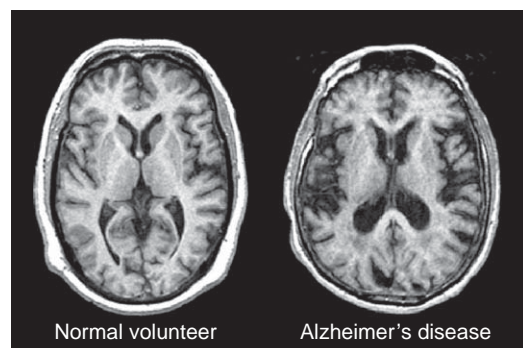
Typical MRI in AD.
